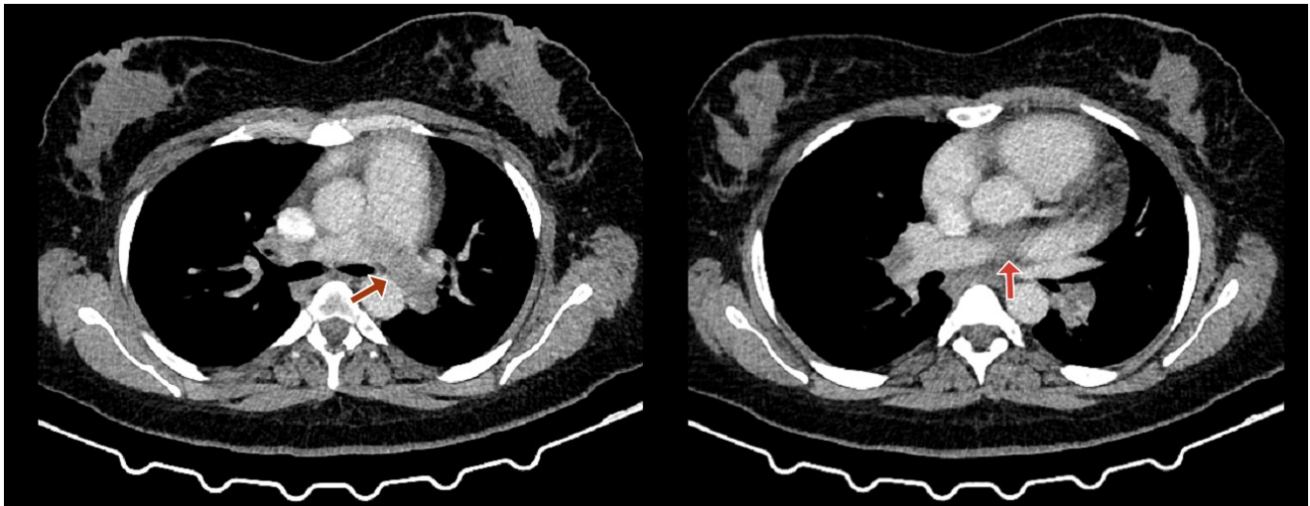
CT angiography of pulmonary vasculature showing filling defects (low attenuation areas) in both the right and left pulmonary arteries, consistent with pulmonary embolism (PE).
